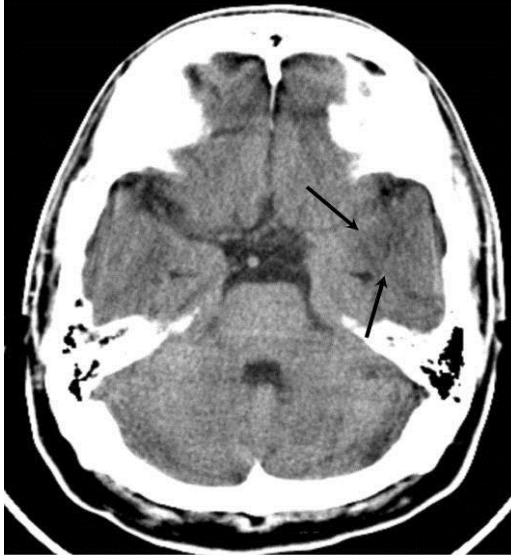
CT Scan of a brain with a glioma
